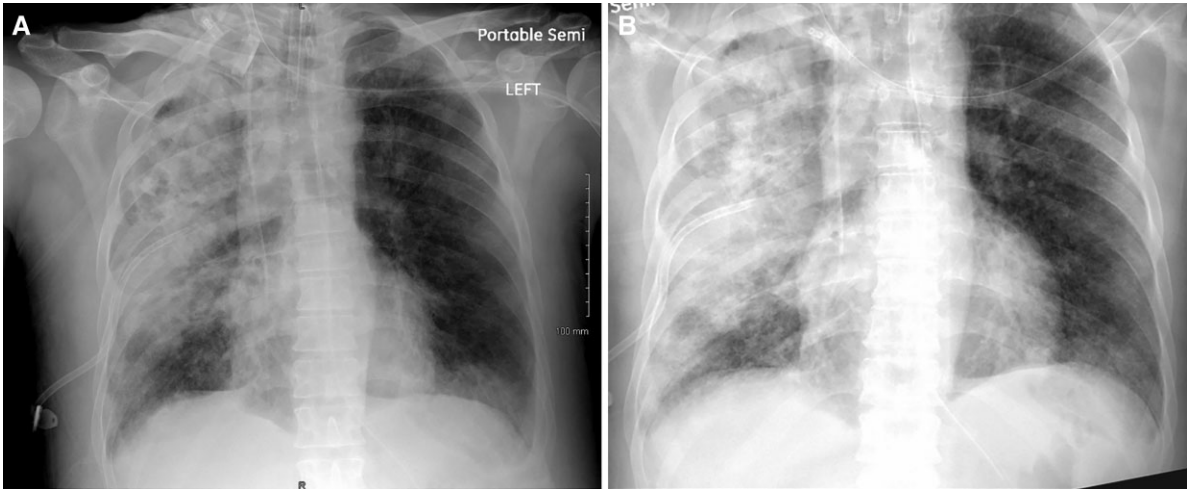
A, Portable chest radiograph of case patient 1 from hospital day 13, 1 day before antitoxin dose 2, showing slight radiographic improvement, especially on the left. B, Portable chest radiograph of case patient 1 from hospital day 15, 1 day after antitoxin dose 2, showing persistent bilateral pleural and parenchymal opacities, decreased aeration at right lung base, and increased aeration on left.
